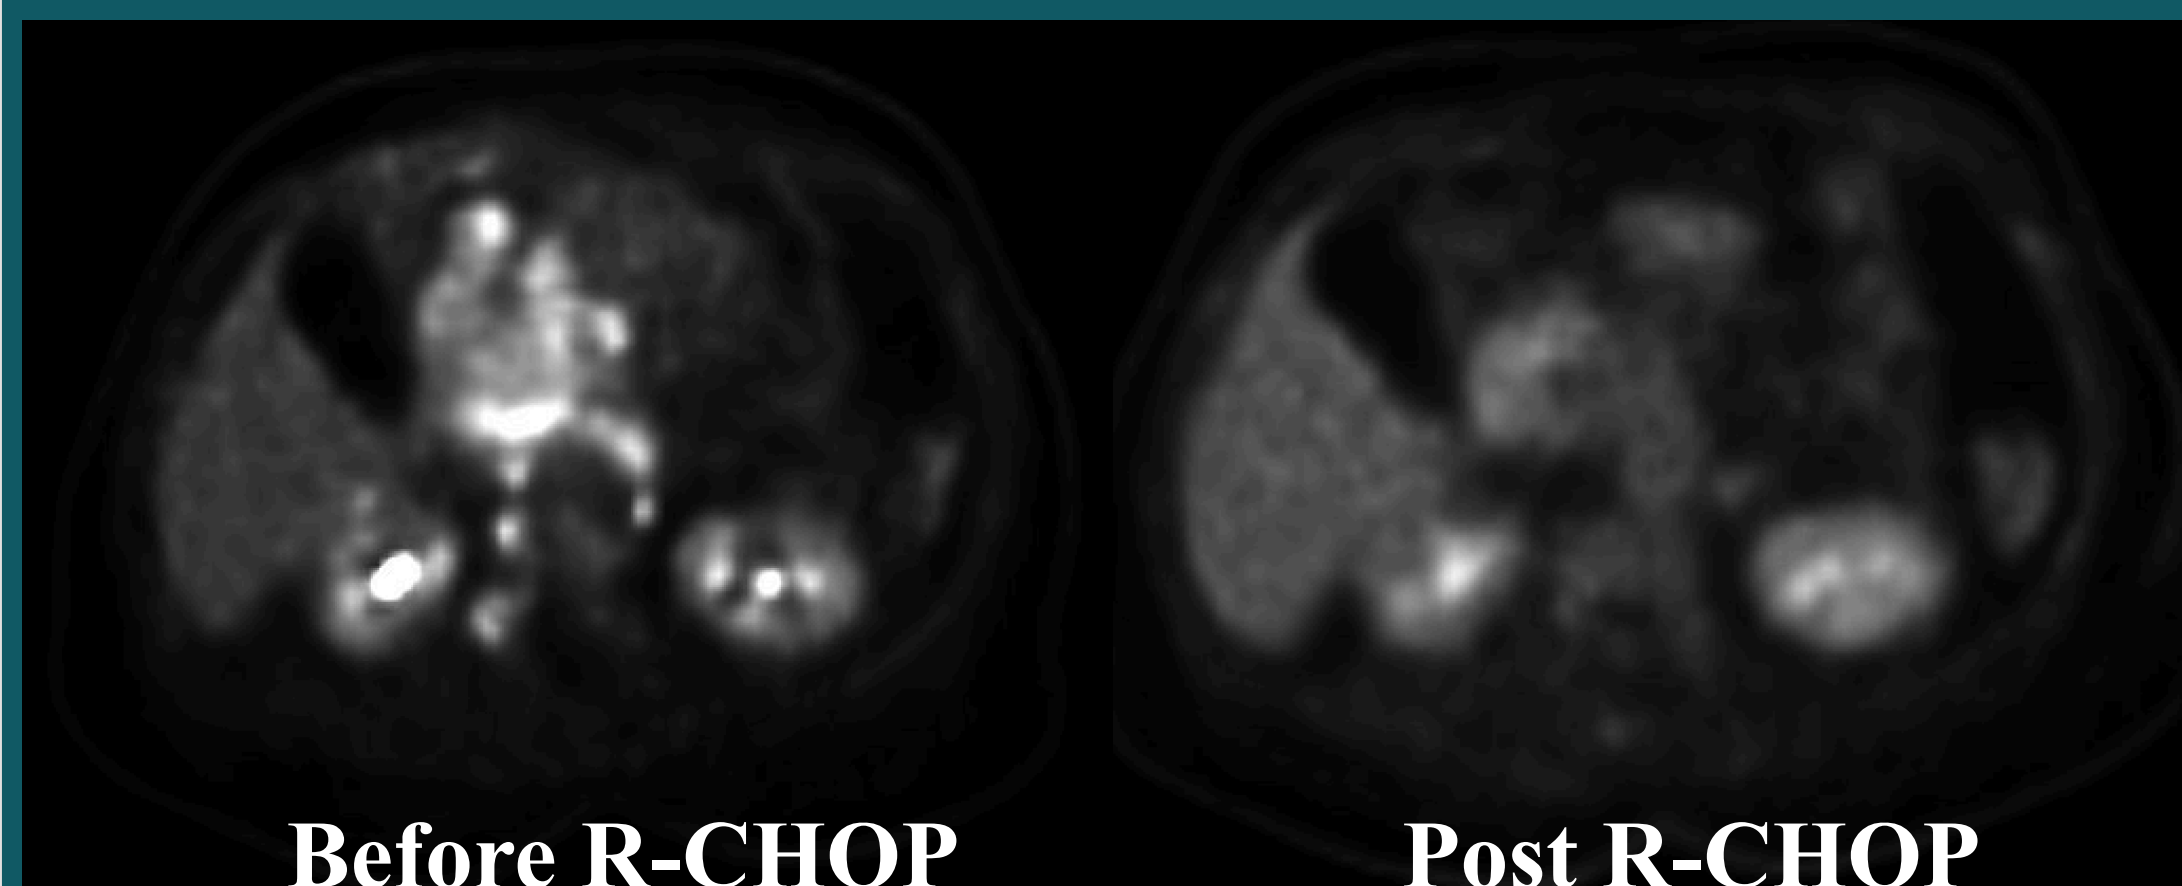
PET/CT abdomen pelvis prior to initiating R-CHOP with hypermetabolic adenopathy (left) and repeat PET/CT after 6 cycles of R-CHOP without focal areas of hypermetabolism (right)
